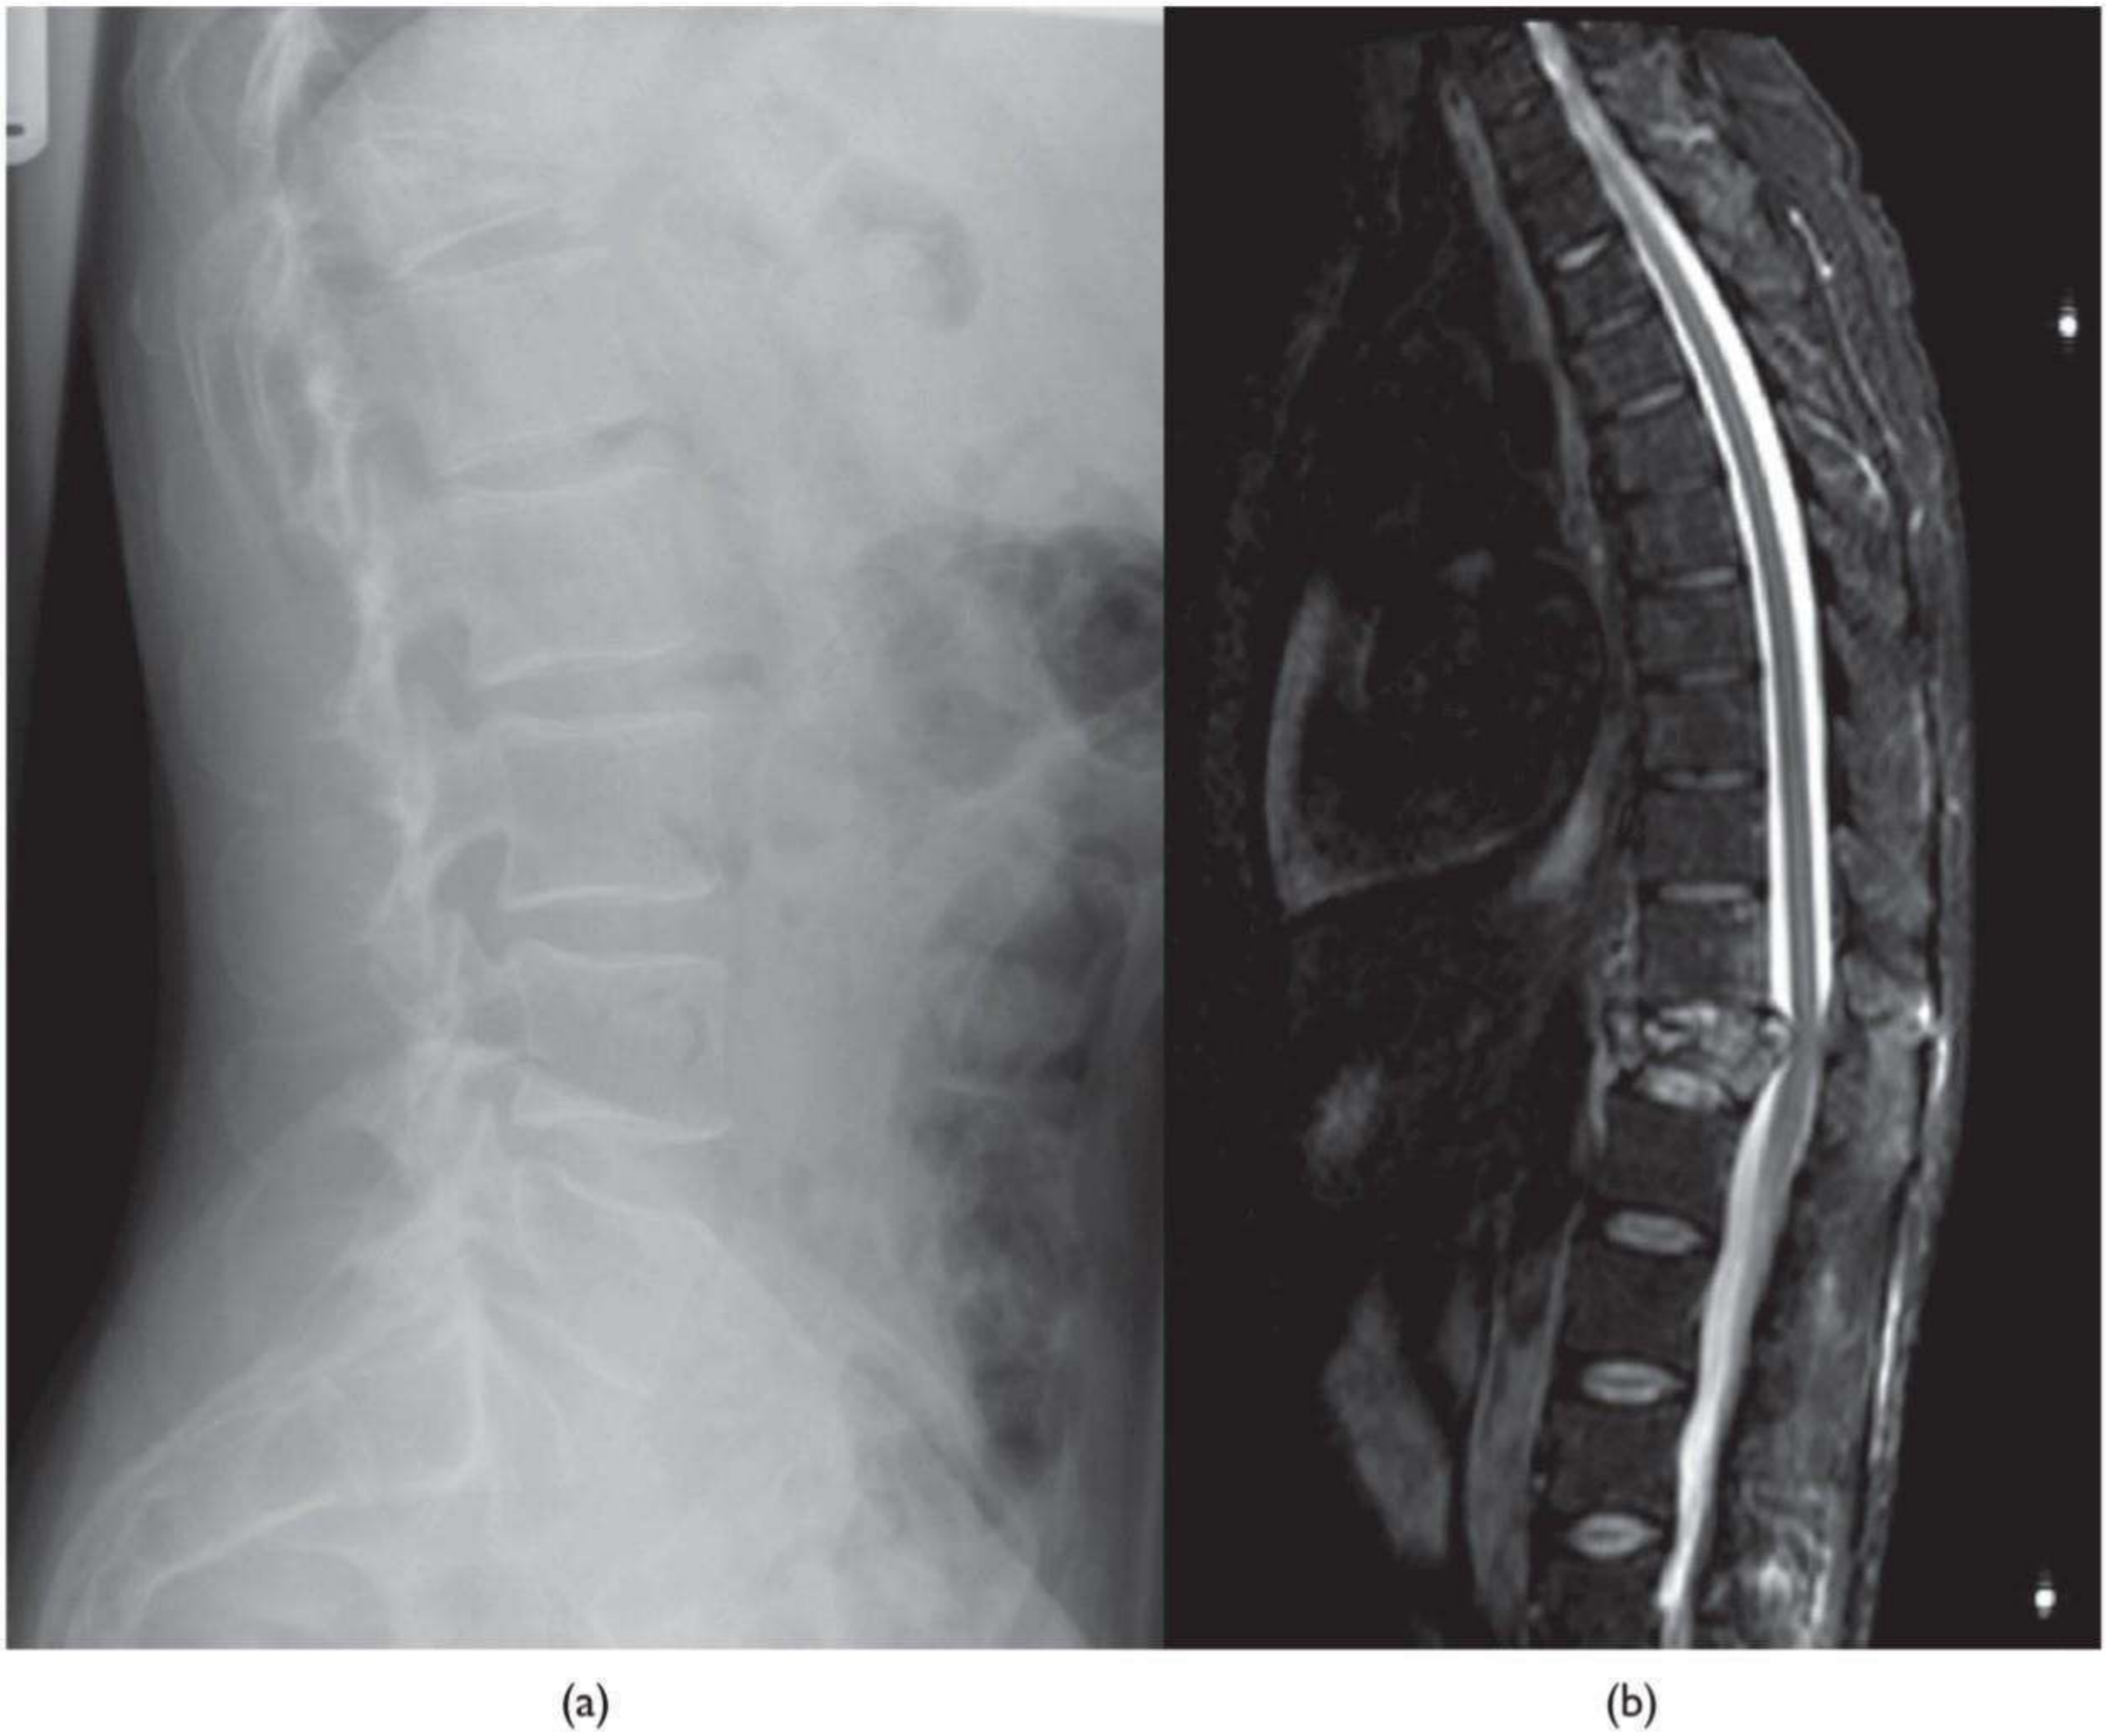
Lumbar spine: radiograph (a) and MRI (b)
